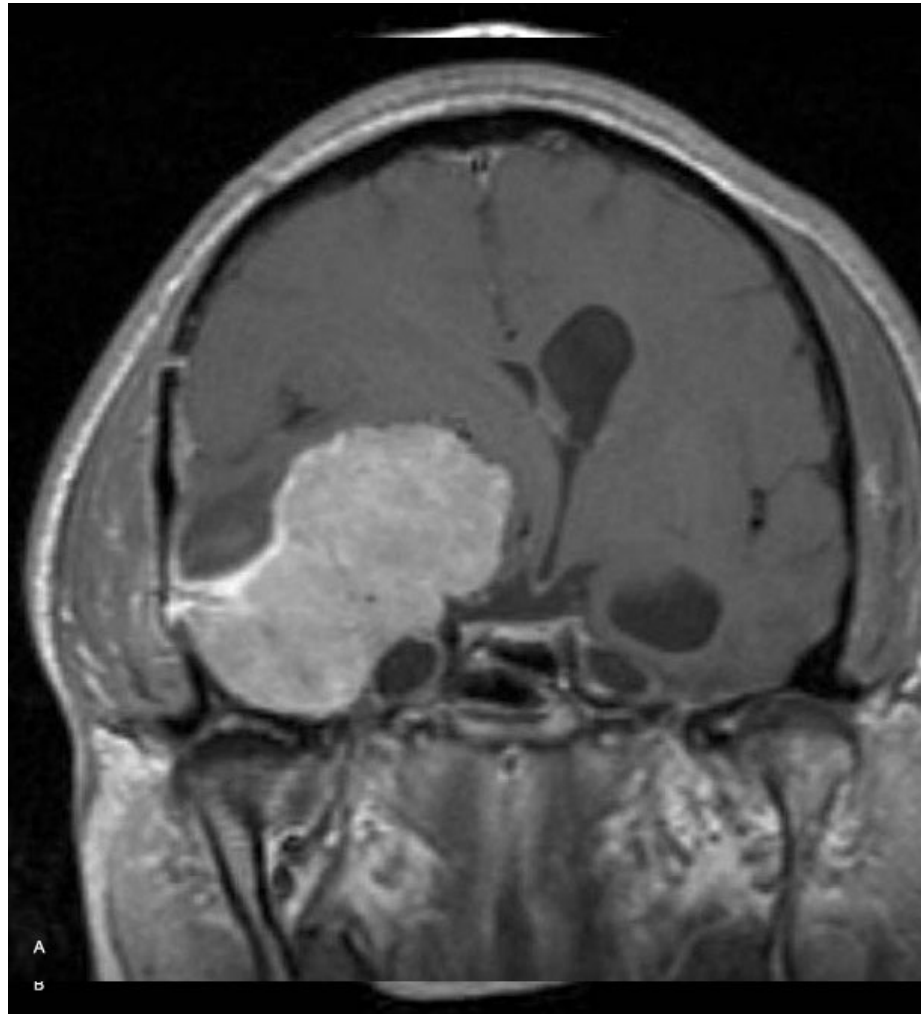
Large medial sphenoid wing meningioma seen on postcontrast MRI in the coronal (A) and axial (B) views. Because of its pedicular attachment lateral to the cavernous sinus and lack of bony involvement of the petrous apex, a complete resection was readily accomplished (C).
